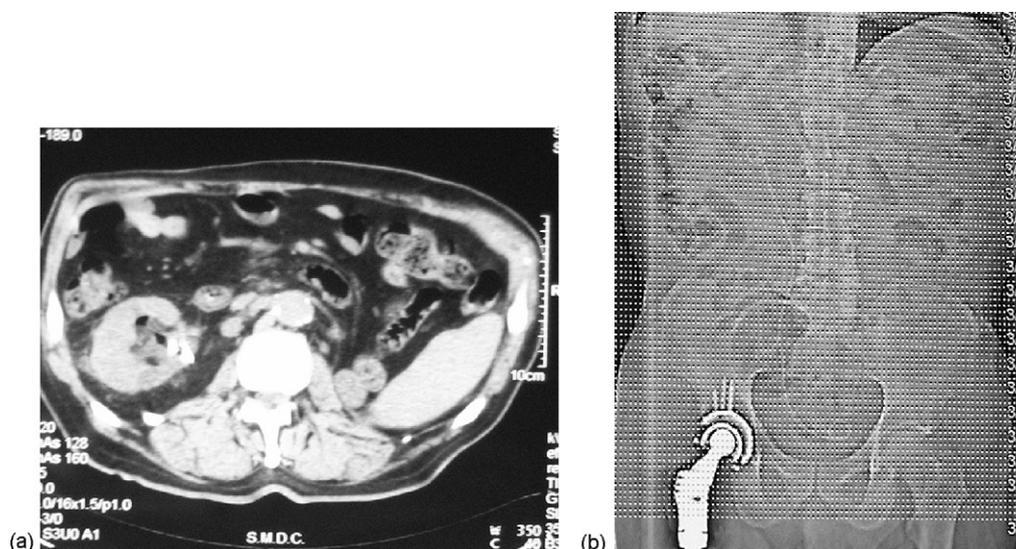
CT scan showing no evidence of local recurrence at right kidney level (a) and cemented endoprosthesis at right femoral level (b).
